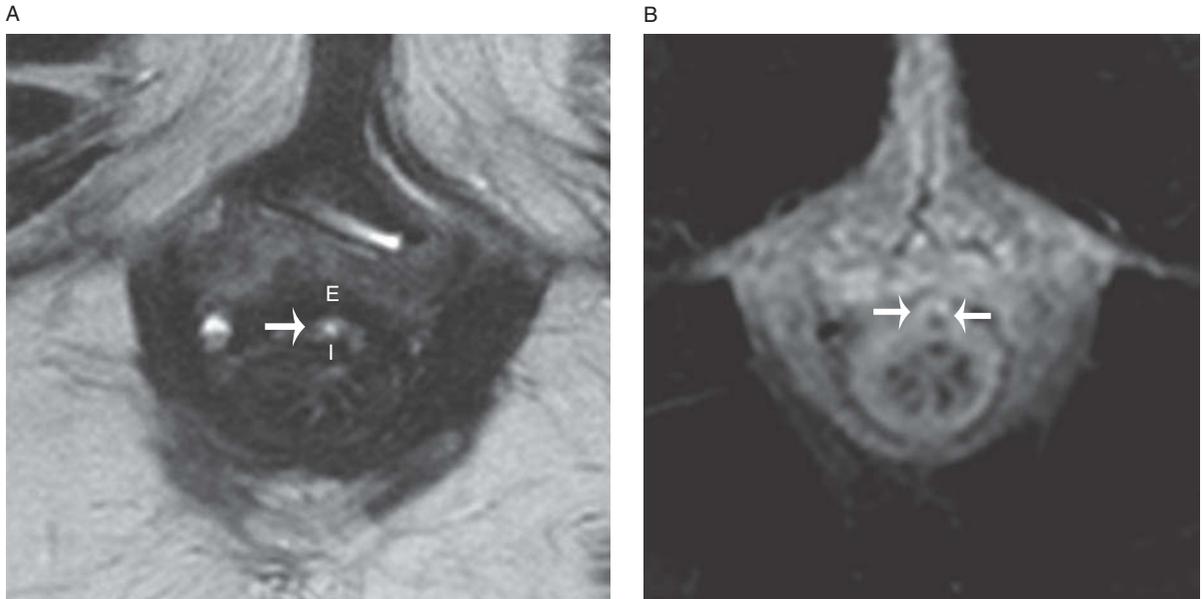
Active intersphincteric fistula in a 42-year-old female. Axial T2-weighted image (A) shows a high T2 signal intensity fistula (arrow) between the internal (I) and external (E) anal sphincter muscles. Axial contrast-enhanced T1-weighted image with fat saturation (B) demonstrates fistula wall enhancement (arrows).
